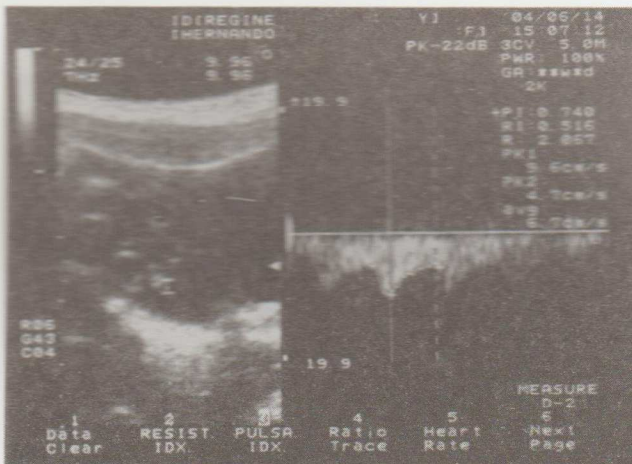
Doppler studies showing pulsatile and resistance indices.
